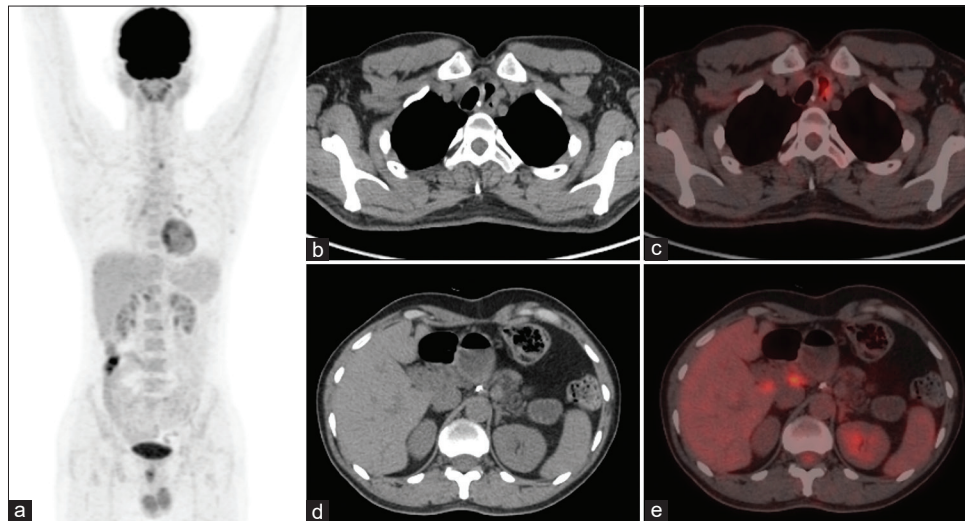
Case of 47-year-old male who underwent chemoradiotherapy and surgical resection (with gastric pull-up) for squamous cell carcinoma of the esophagus. The patient underwent surveillance FDG Positron emission tomography/computed tomography (a [MIP]; b, d [Axial computed tomography]; and c, e [Axial Positron emission tomography/computed tomography]) 6 months after treatment, which postsurgical recurrence in the para-esophageal lymph node (b and c) and peri-, porto-caval lymph nodes. Also note that all nodes were subcentimetric with low tumor burden, which further emphasizes the sensitivity of 18F-FDG Positron emission tomography/computed tomography
